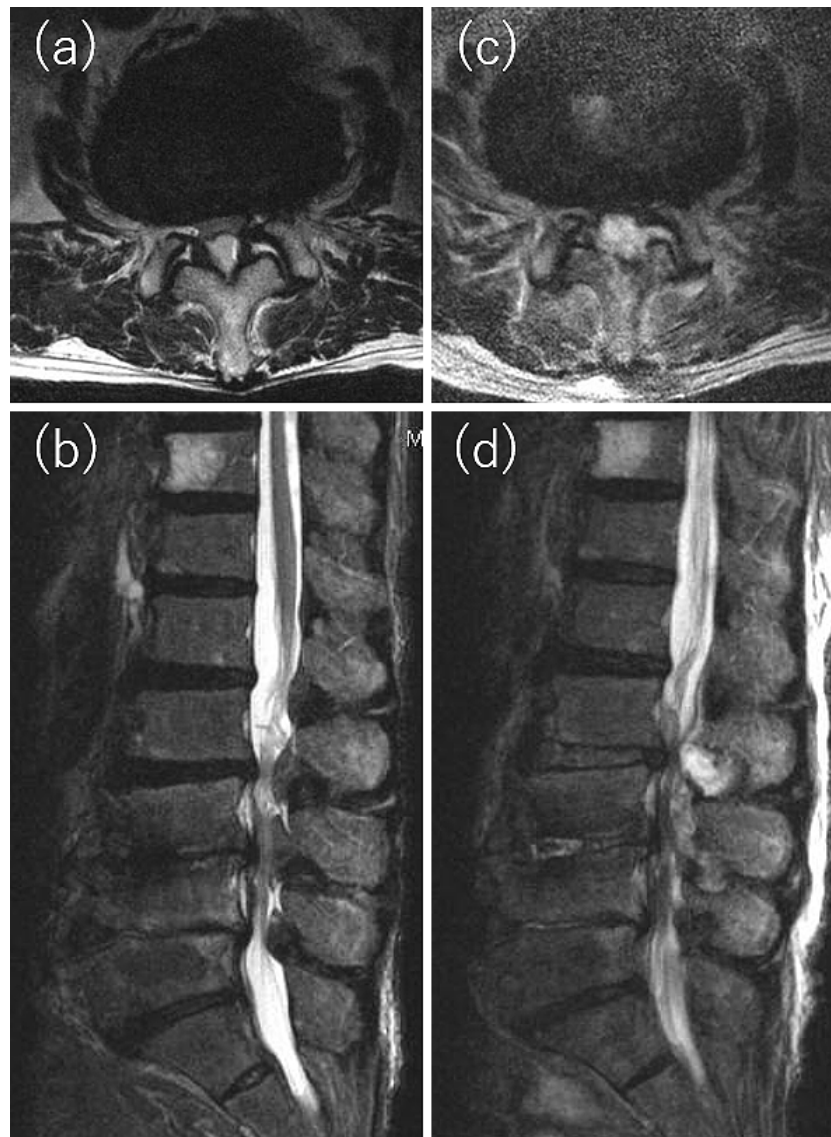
Representative MRI findings. (a) Preoperative axial plane at L2/3. (b) Preoperative sagittal plane. (c) POSEH at L2/3. (d) POSEH after L2/3, L3/4, and L4/5 MEL [Abbreviations] MEL, microendoscopic laminectomy; POSEH, postoperative spinal epidural hematoma
